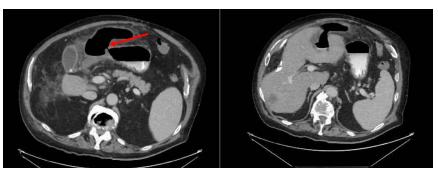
A CT scan 12 days after ablation showing free communication between the stomach and the peritoneum forming a sealed perforation; the arrow points toward the free perforation between the liver and the stomach. CT, computed tomography.
